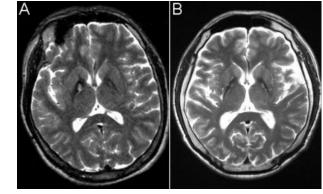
Magnetic resonance imaging of the brain showing hypointensity with a central region of hyperintensity in the medial globus pallidus, the eye of the tiger sign (Case 1, A) or a faint hyperintensity region within a slit hypointensity region in the medial globus pallidus (Case 2, B).
